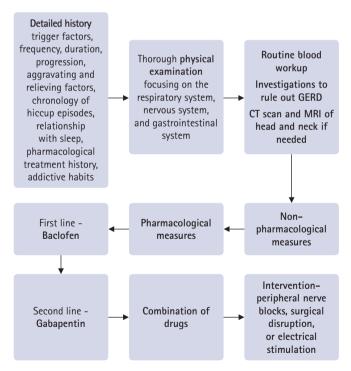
Stepwise management protocol. GERD, gastroesophageal reflux disease; CT, computed tomography; MRI, magnetic resonance imaging.
